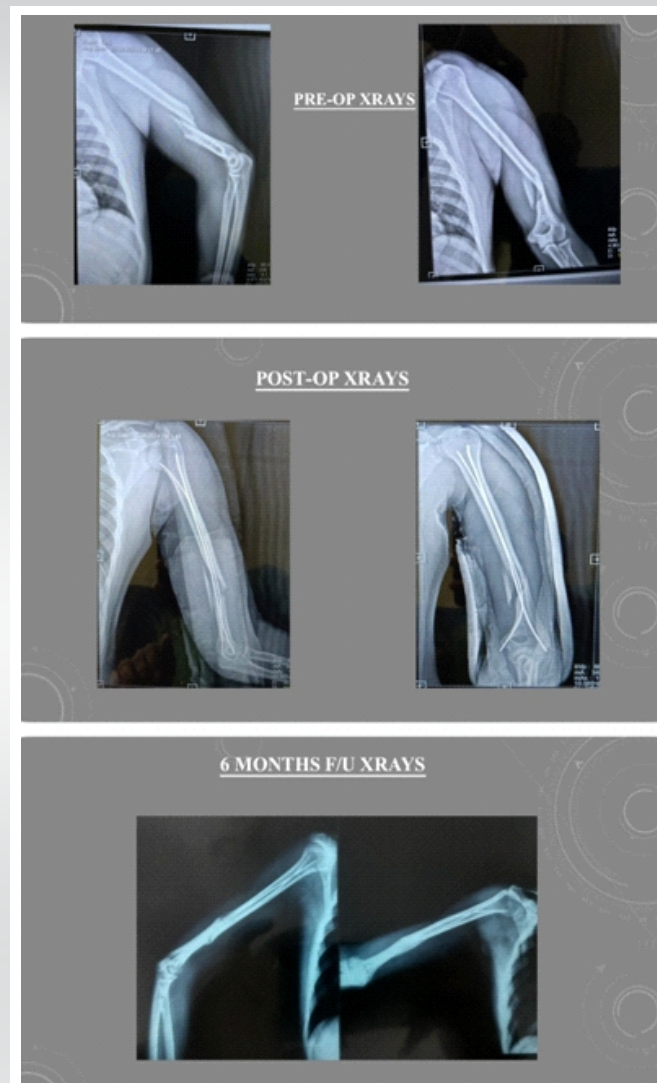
(a and b) Comminuted fracture pre-operative and post-operative radiographs – Case 3.
